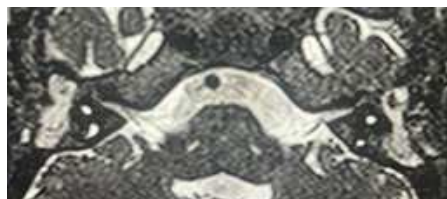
MRI CISS image shows narrowing of bilateral internal auditory canal
